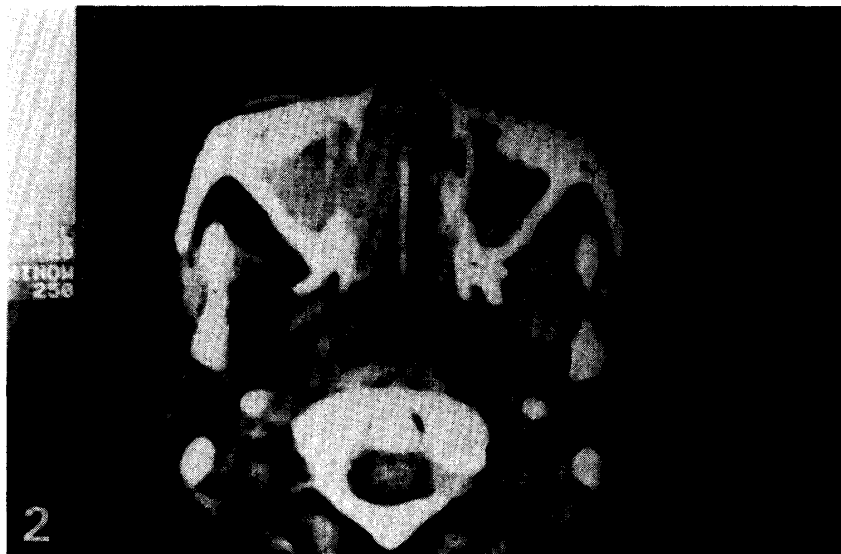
CT scan shows a tumor mass lesion in the right nasal cavity and maxillary sinus.
